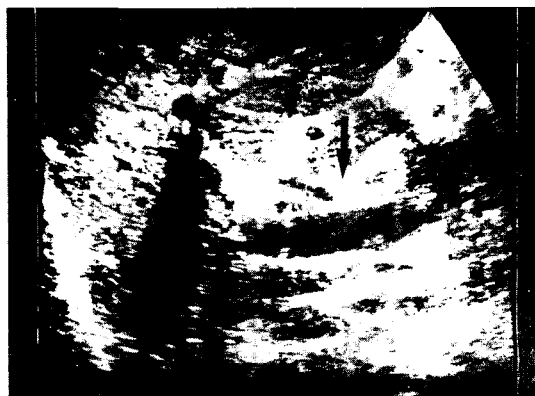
Sonogram of the liver showing echogenic thickening (arrow) of the wall of the portal vein (PV) in hepatosplenic schistosomiasis.
